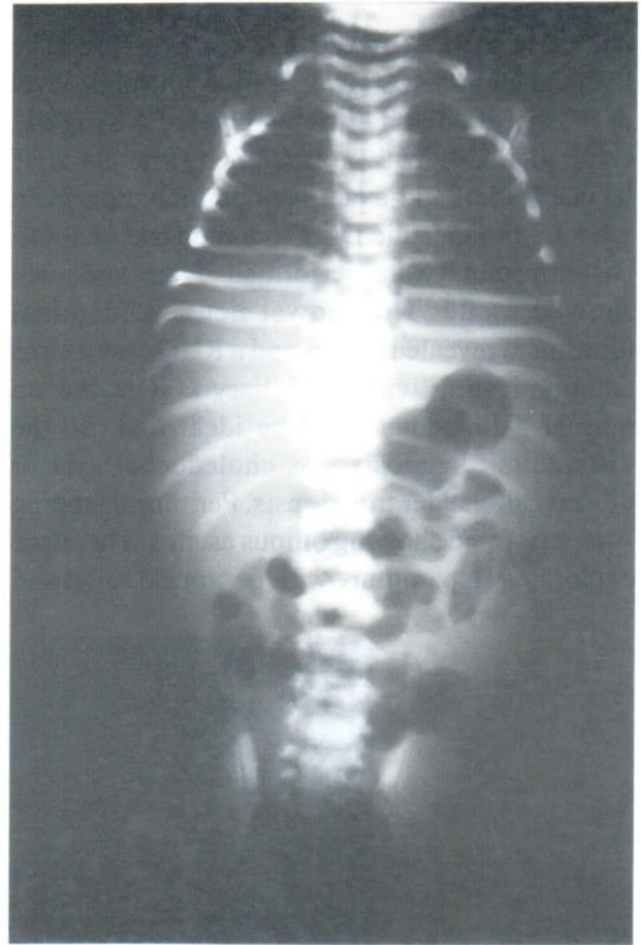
Plain film of the abdomen in case 3 showed ascites with bowel ileus
